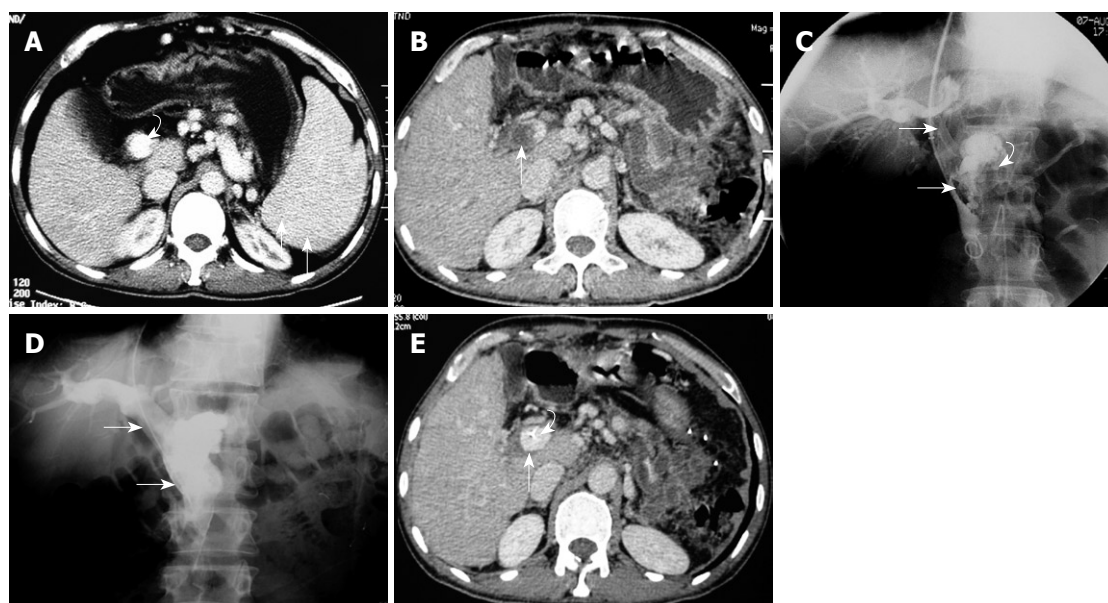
Case 1: A 40-year-old man with low-grade fever, abdominal pain, distension, and nausea for 12 d. He had undergone splenectomy 4 wk previously. A: Selected axial image from before open splenectomy contrast-enhanced CT shows splenomegaly (arrows) and patent portal vein (curved arrow); B: Selected axial image from admission contrast-enhanced CT, on postoperative day 28, shows massive thrombus within the PV (arrow); C: Pre-treatment direct venography via transjugular approach access to the portal vein shows massive thrombosis of the PV extending into the SMV (arrows). Note the stump of the splenic vein (curved arrow); D: Follow-up direct portal venography via the infusion catheter, obtained 5 d after the catheter infusion of thrombolytics, shows patency of the main PV-SMV (arrows); E: CT image at the same level as in Figure 1B obtained 5 d after the interventional procedure, before the infusion catheter removal, shows the wide patent main PV (arrow). Note the infusion catheter within the PV (curved arrow).
